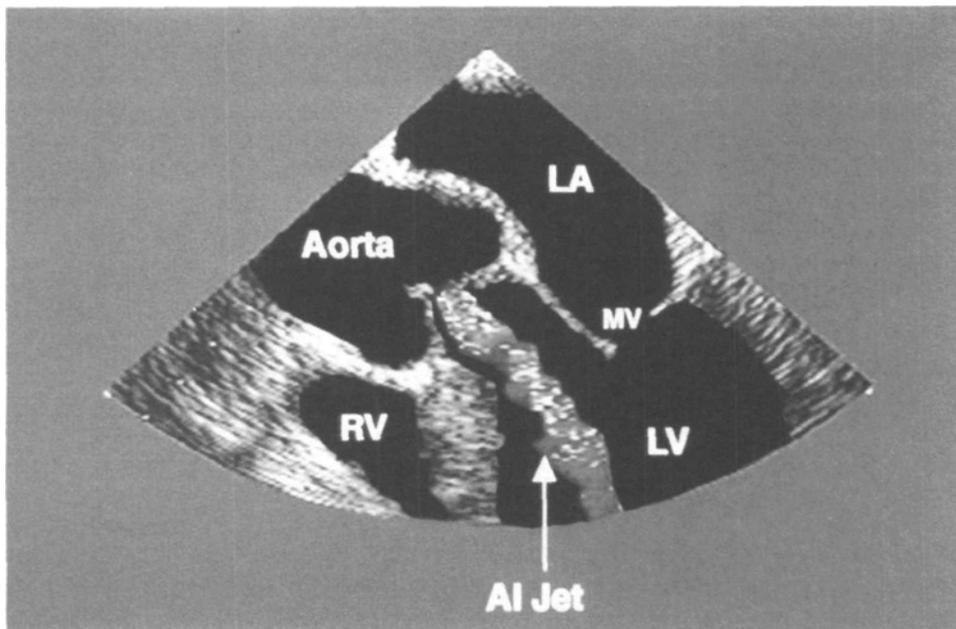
Aortic regurgitation. With colour Doppler applied to the three chamber view in diastole, a regurgitant jet is seen passing through the aortic valve into the LVOT and LV.
